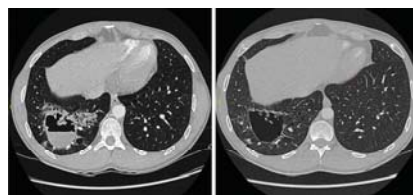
(Left) Chest computed tomography at presentation showed a lung abscess in the right lower lobe. (Right) After treatment a residual thin-walled cystic structure in the right lower lobe persisted.
